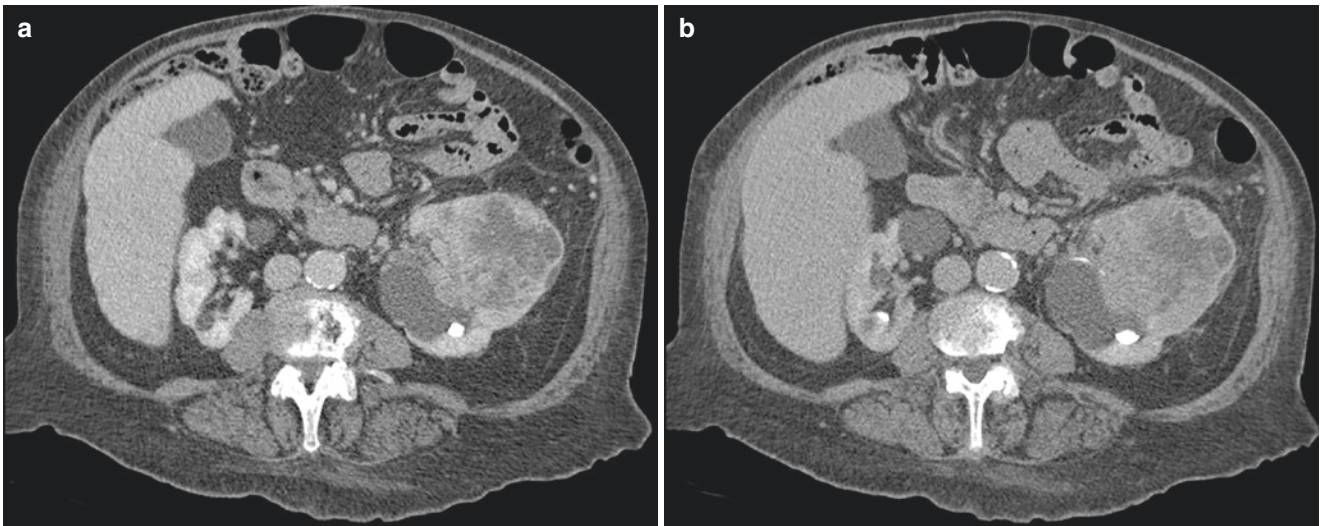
RCC with sarcomatoid differentiation, radioimages. (a) CT scan shows a large, peripherally enhancing heterogeneous mass with suspected invasion of the proximal ureter as well as possible thrombosis
